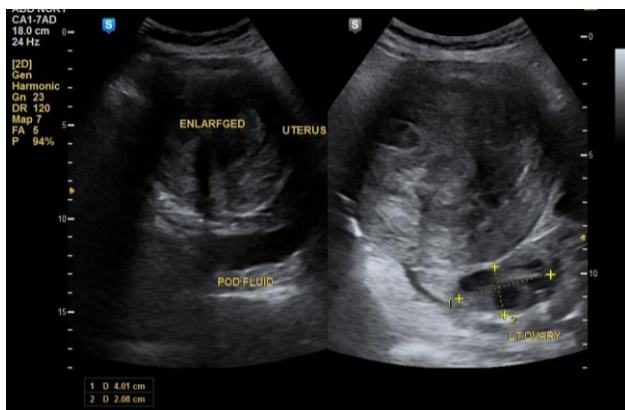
Grey scale ultrasound image demonstrates predominantly hypoechoic fibroid within the enlarged uterus, minimal POD fluid and left ovary
